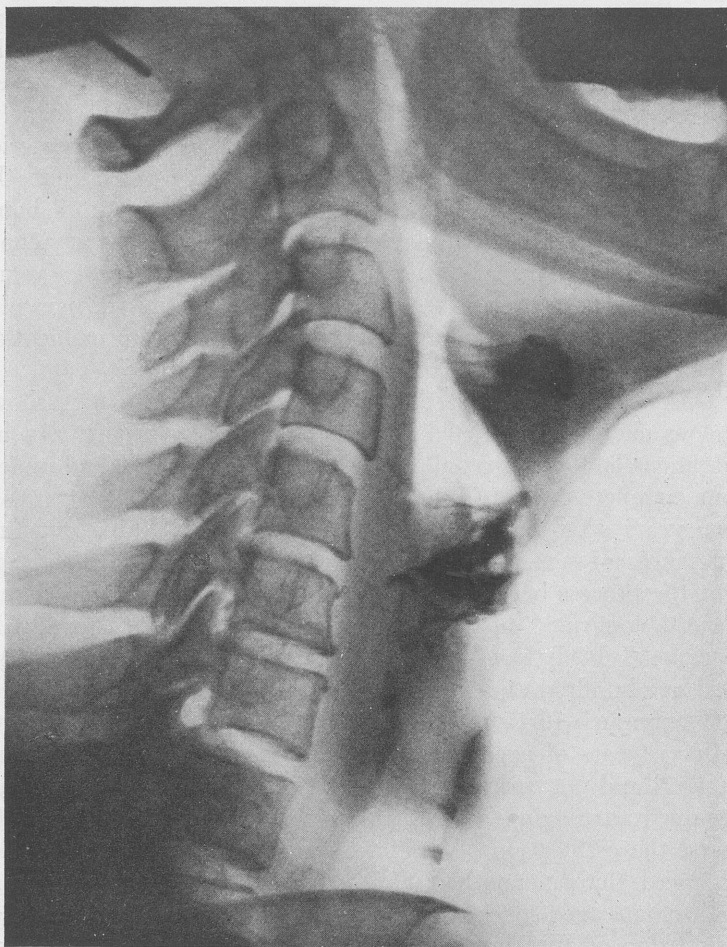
A roentgenogram of the larynx of a woman, aged fifty-five years. The thyroid cartilage shows marked ossification except at the round or oval windows which represent remaining cartilage. The superior and inferior cornua also show ossification.
